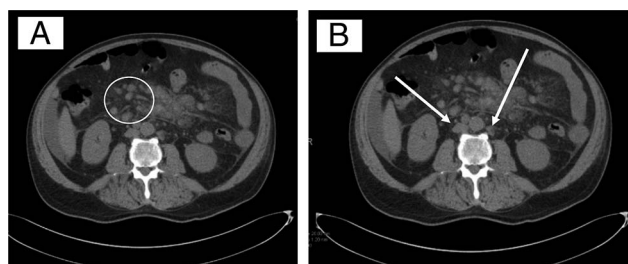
Computed tomography of abdomen and pelvis showing extensive mesenteric (A - circle) and retroperitoneal (B - arrows represent retroperitoneal lymph node) lymphadenopathy.
